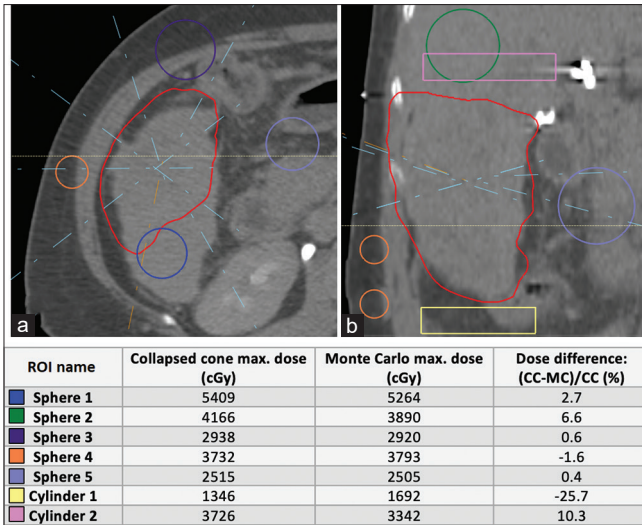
Comparing maximum dose from CC and MC to OARs on water-density CT image. An (a) axial and (b) coronal cross section of the patient CT image set to water density (original CT numbers shown). The red contour is the target, and the colored spheres and cylinders are ROIs, labeled in the left column of the table. The dashed lines represent the center of the beams. The axial cross section in a) shows the ROIs lateral to the target (spheres 1, 3, 4, and 5) and the coronal cross-section in b) shows the superior/inferior ROIs (sphere 2, cylinder 1, and cylinder 2). The table below the images shows the maximum dose calculated for each ROI using CC and MC, as well as the percent difference of the two algorithms. OARs: Organs at risk, CC: Collapsed cone, MC: Monte Carlo, CT: Computed tomography, ROIs: Region of interest
